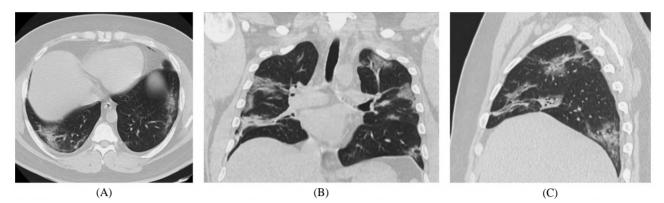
38 years old male confirmed positive for COVID 19 infection. (A): Axial CT chest cuts showed sub-pleural line, peripheral parenchyma bands with sub-pleural ground glassing & consolidations. (B&C): Coronal and sagittal images confirmed the multi-segmental involvement with no lobar predilection.
